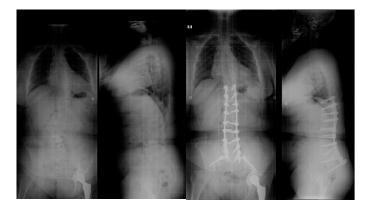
Standing preoperative/postoperative radiographs in the anteroposterior and lateral projections of a 66-year-old woman who underwent posterior instrumentation from T10-ilium (conventional iliac screw). Please note that offset connectors were used to place the rods. LL improved from 40° to 53° and SVA remained same
